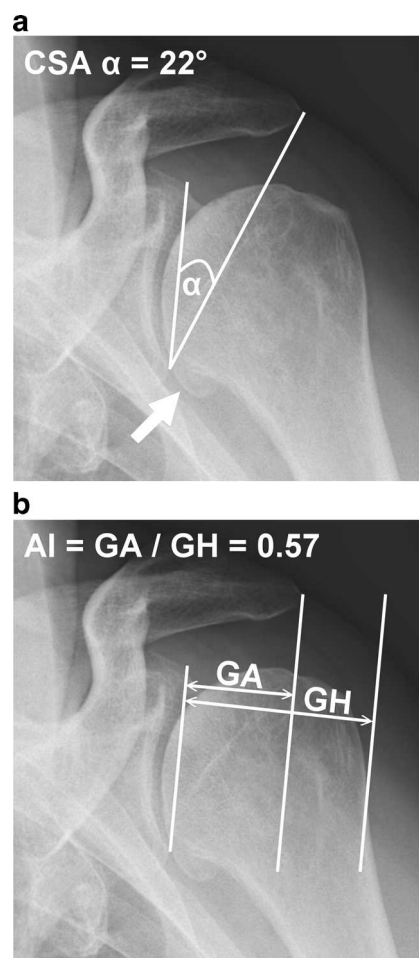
A 55-year-old man with osteophytes (a, bold white arrow) and moderate radiographic joint space narrowing inferiorly indicative of osteoarthritis of the glenohumeral joint. The critical shoulder angle α (CSA, A) of 22° and the acromion index (AI) of 0.57 (b, AI = ratio between distance GA and GH) represent the short lateral extension of the acromion process, which has been related to osteoarthritis of the glenohumeral joint
